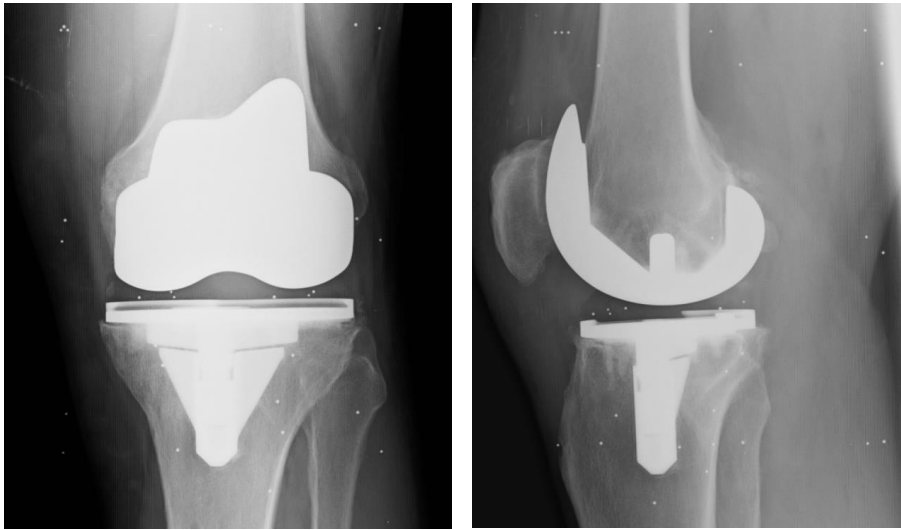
Postoperative radiographs of a knee with RSA markers.
